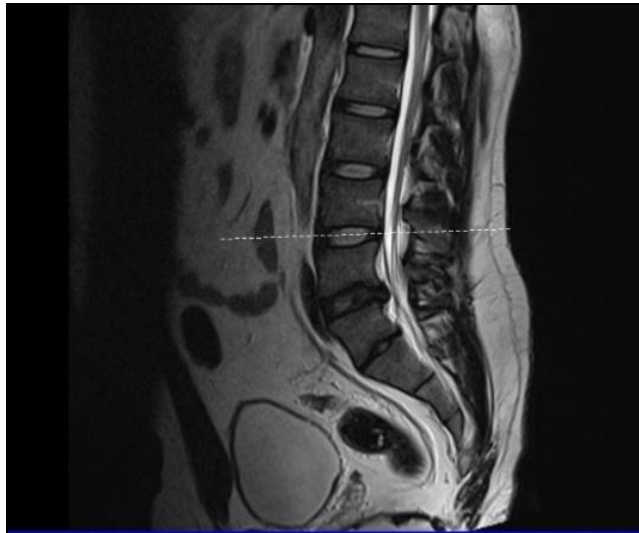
MRI picture: Sagittal section of spine to confirm perpendicularity of plate
